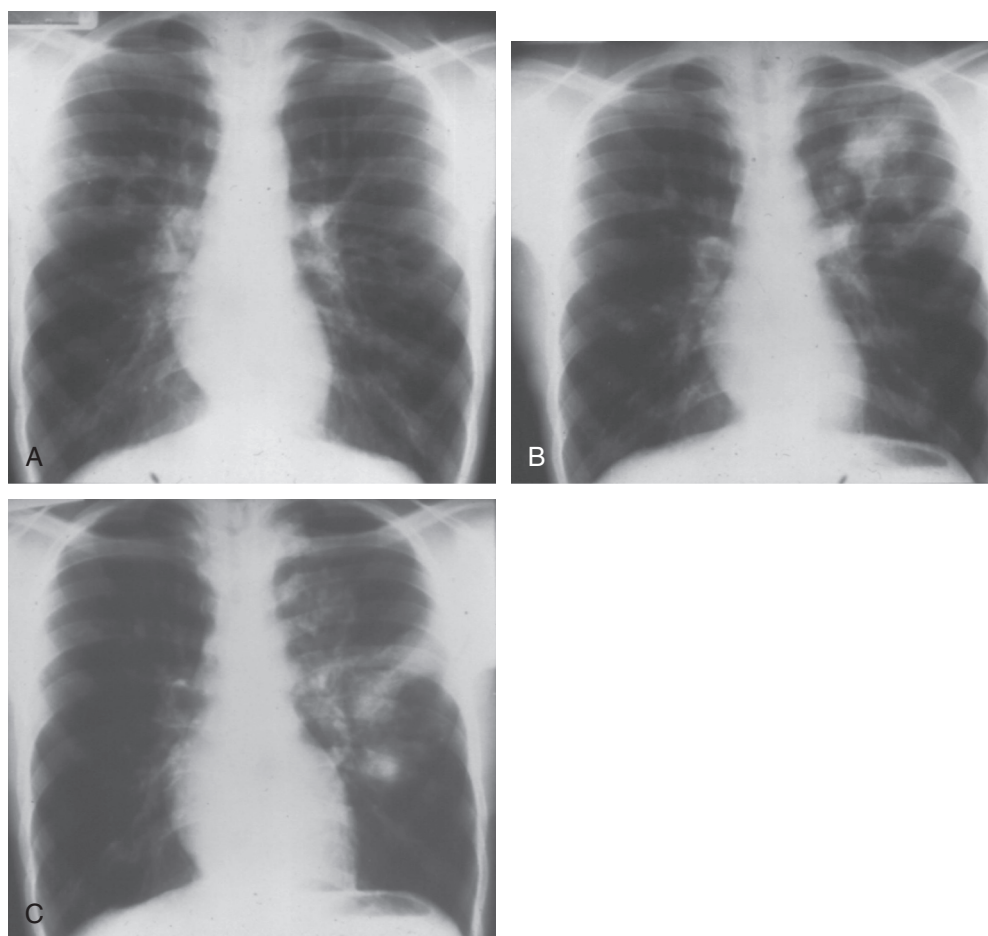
Chest radiographs demonstrating fleeting infiltrates in the case of ABPA. A, Soft nodular infiltrates in the right upper lobe suggest tuberculosis. B, Fourteen days later, there is some clearing on the right with a new infiltrate present in the left midlung field. C, Ten days later, the left midlung has cleared but a new infiltrate is present in the upper lobe. (From Slavin RG: Allergic bronchopulmonary aspergillosis. In Fireman P, Slavin RG [eds]: *Atlas of Allergies*, 2nd ed. London, Mosby-Wolfe, 1996, pp 131–139.)
